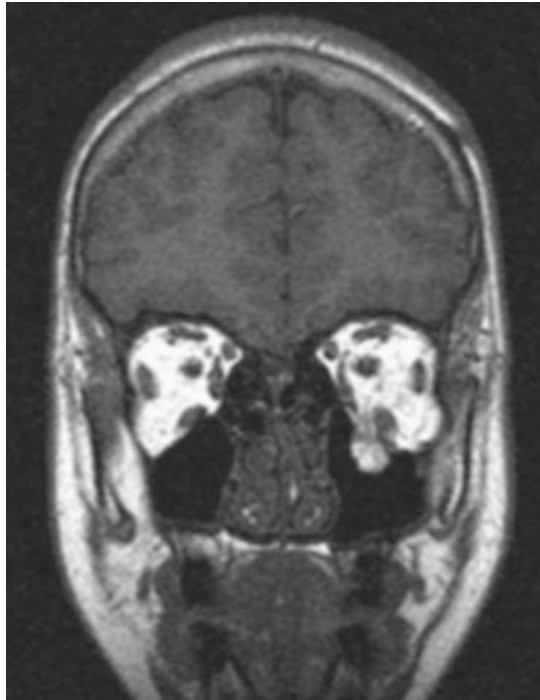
Single sequence MRI of an orbital floor fracture with blow-out of the orbital fat into the maxillary sinus on the left: fast, radiation-free and all the surgeon needs to know.
